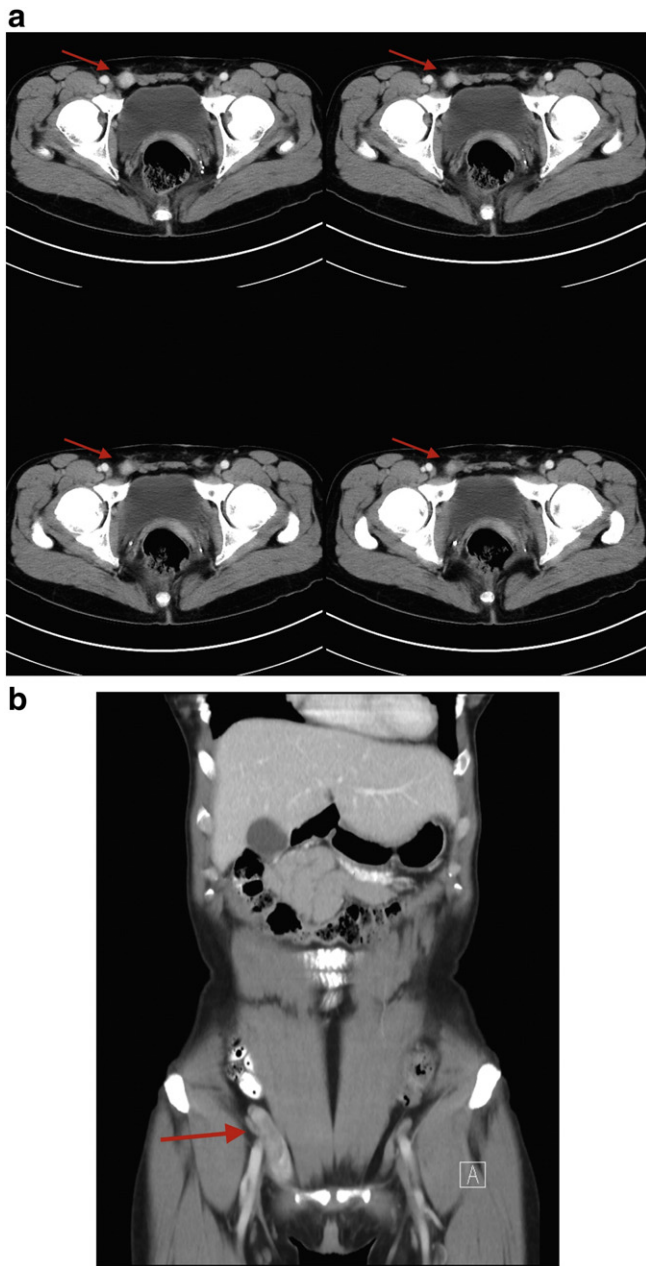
(a & b) Forty-nine-year-old woman with right groin pain. Axial CT images demonstrate an ovoid enhancing soft tissue mass above the superficial inguinal ring (Fig. 1a), best appreciated on the coronal projection (Fig. 1b).
